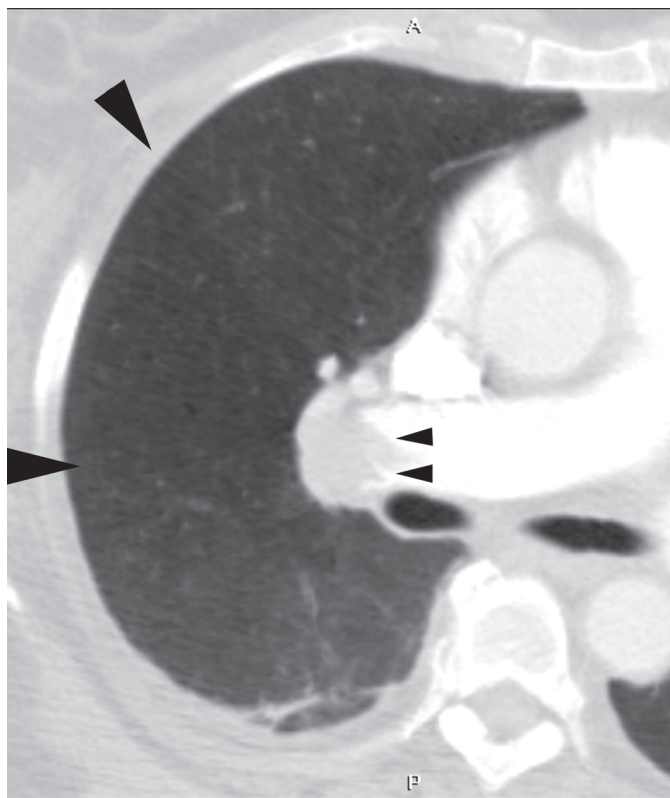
Computed tomography Westermark sign. Thin-slab axial minimum intensity projection image reveals wedge-shaped region of hypoperfusion (large arrowheads) relative to normal parenchyma due to central pulmonary embolism (small arrowheads).
